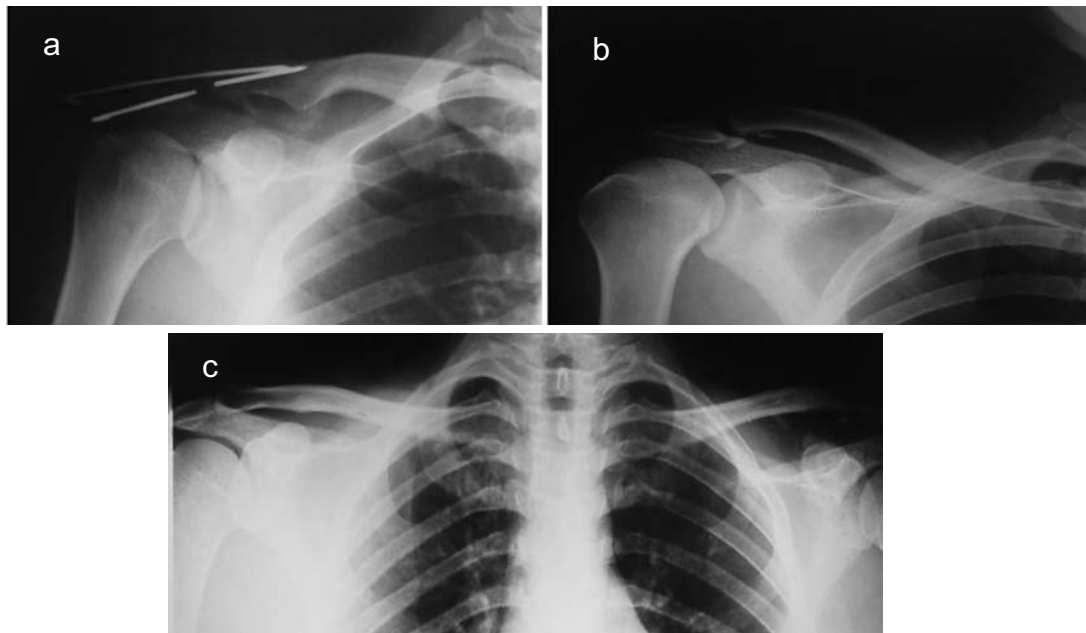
Case 1. A 29 year old male patient with left AC joint injury treated with pin fixation. a: Preoperative x-ray; b: Postoperative x-ray; c: Postoperative x-ray after pin removal. An increase in the coracoclavicular space in comparison to the normal shoulder was detected.
